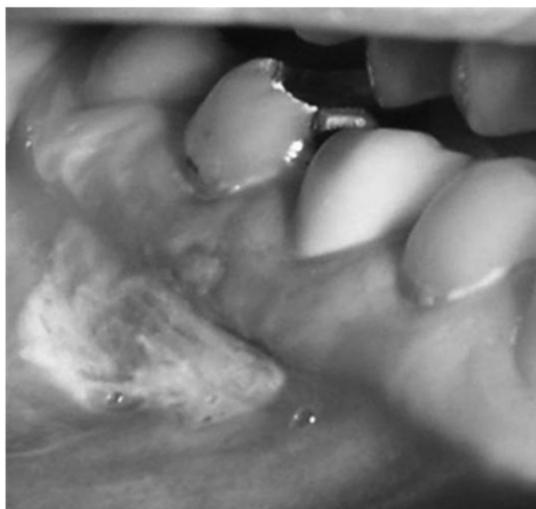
An area of soft tissue necrosis surrounded by well-vascularized tissue near the periapical area of tooth #46
